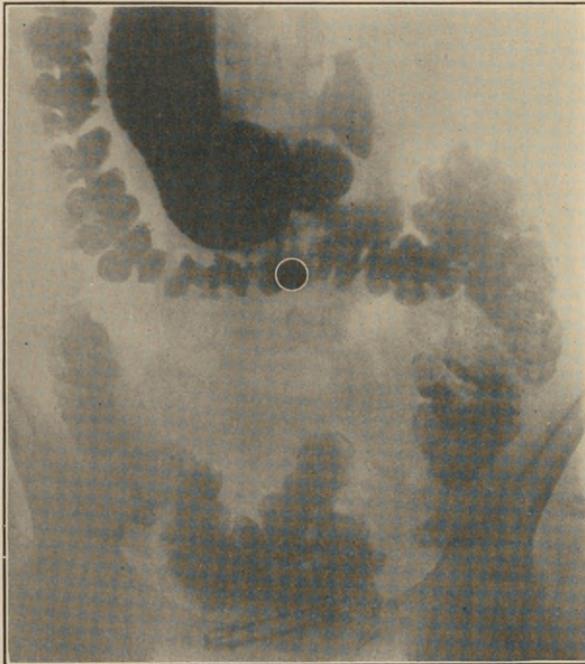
ROENTGENOGRAM OF SAME STOMACH SHOWN IN FIG. 200A. (Courtesy of Dr. Sears, who directed the treatment.)
